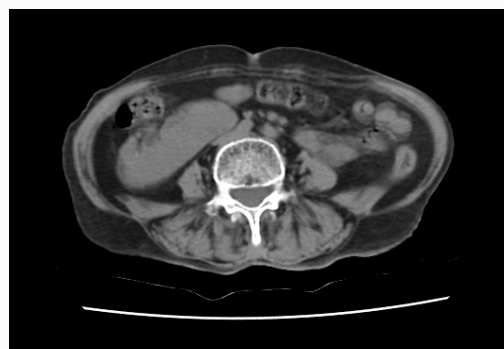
CT scan of abdomen showing crossed fused kidneys.
